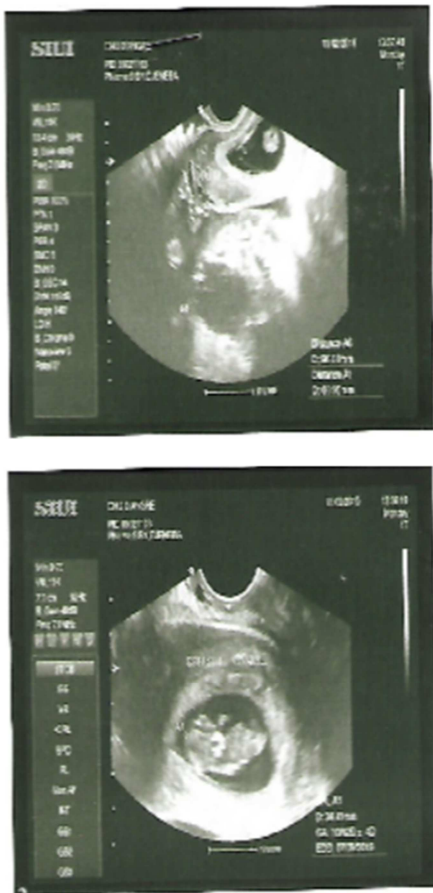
Obstetric ultrasound Progressive pregnancy of 10 weeks associated with a right ovary cyst of 96 mm x 60 mm.
